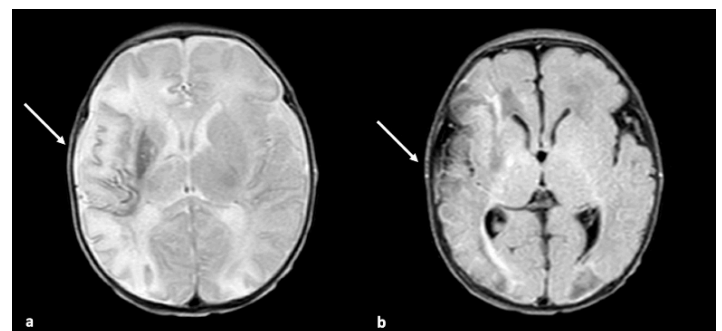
Magnetic resonance imaging T2 (a) and fluid-attenuated inversion recovery (b) demonstrating hyperintensity and diffusion restriction involving the right middle cerebral artery and anterior cerebral artery distribution consistent with infarct (white arrows).
